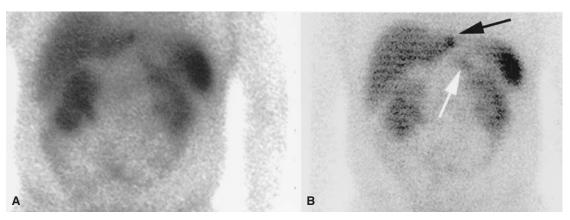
Somatostatin receptor scintigraphy in one patient in consecutive annual examinations, demonstrating the development of a left lateral segment liver metastasis from a known pancreatic body tumor. *A*, On the initial study, a focus of uptake was noted in the body of the pancreas, but no increased activity was appreciated in the liver, including evaluation with single-photon emission computed tomography (SPECT). The pancreatic lesion (*light arrow in B*) was confirmed on abdominal computed tomographic (CT) scan but measured only about 1 cm, and after discussion with the patient, it was elected to follow this abnormality. *B*, One year later, repeat imaging showed a clear left lateral segment liver lesion (*dark arrow*), which was clearly visible on SPECT and not appreciable on the earlier study, even in retrospect. This lesion was confirmed on CT scan. At subsequent laparotomy, a single focus of liver disease was identified by ultrasonography and resected. He remains disease free at 3-year follow-up.
